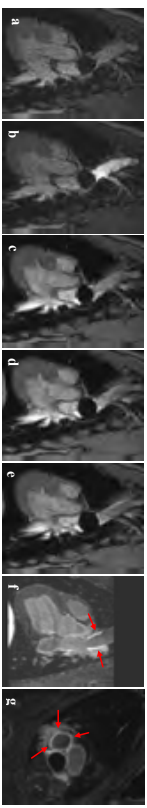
Cryo ablation of SVC-RA junction using MRI-compatible cryo balloon. (a-b) Navigation and validation of SVC occlusion by the balloon (a) pre contrast, (b) after contrast injection; (c-e) Real-time visualization of cryo ablation: (c) pre, (d) 1 minute freeze, (e) 3 minute freeze. (f-g) Assessment of the ablation by LGE-MRI: (f) sagittal and (g) axial views. Red arrows indicate circumferential ablation with no gaps at SVC-RA junction.
